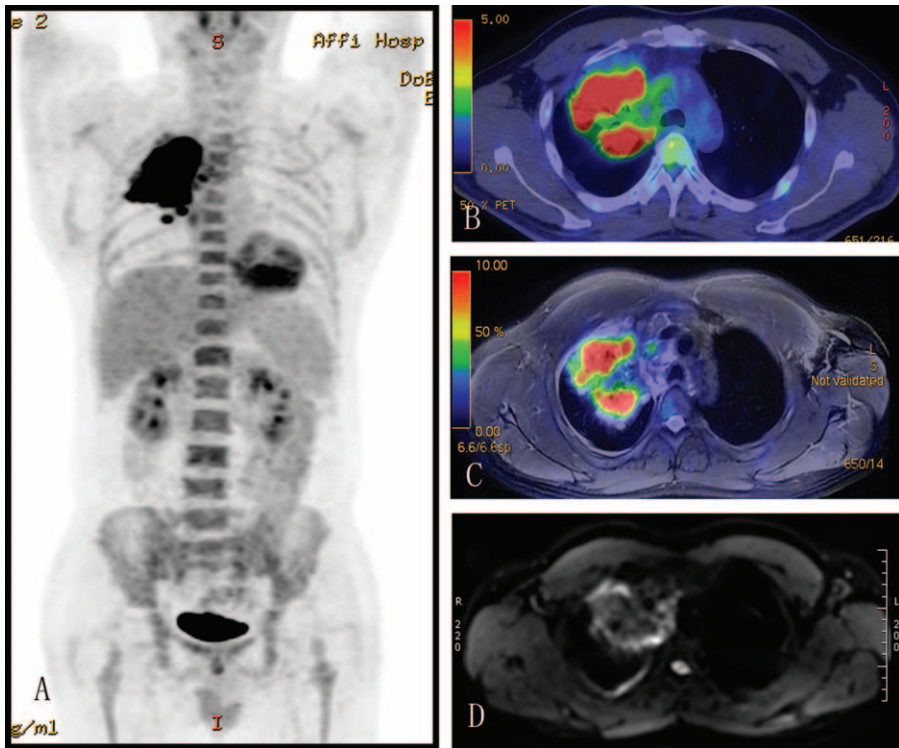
FDG PET/CT-MRI and DWI examinations were performed. The 3-dimensional MIP image in (A) coronal plane demonstrated FDG uptake lesions, including the primary pulmonary lymphoma and mediastinal lymph nodes. Selected axial slices of fused (B) PET/CT; (C) PET/MR images showed abnormal focal FDG uptake. (D) DWI showed heterogeneous high-intensity signal mass, but the interior parts of the bronchus were normal (arrowhead). CT = computed tomography, DWI = diffusion-weighted imaging, FDG = fluorodeoxyglucose, MRI = magnetic resonance imaging, PET = positron emission tomography.
